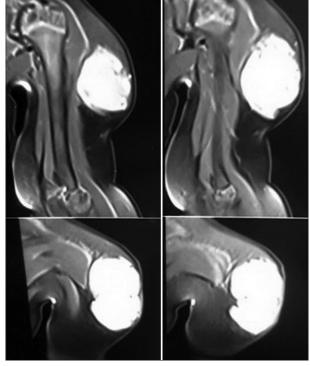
T1 weighted magnetic resonance imaging delineated a multiloculated cystic mass
